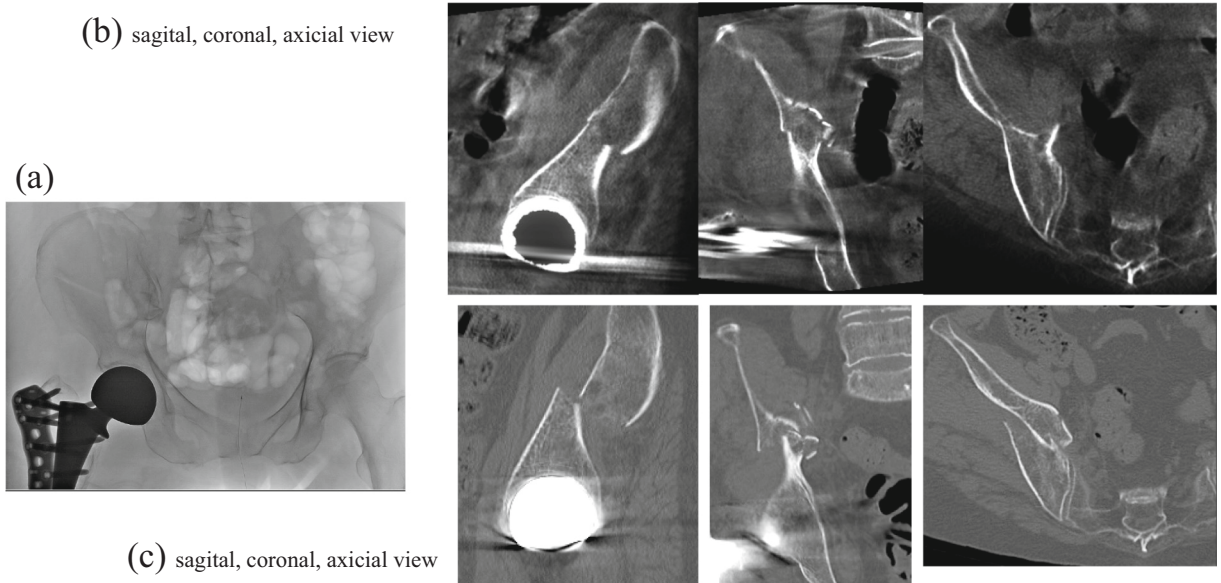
Fluoroscopic image (a) and CT images (b) in prone position after femoral surgery. (c) Pre-operative CT images for comparison to Fig. 2(b).
